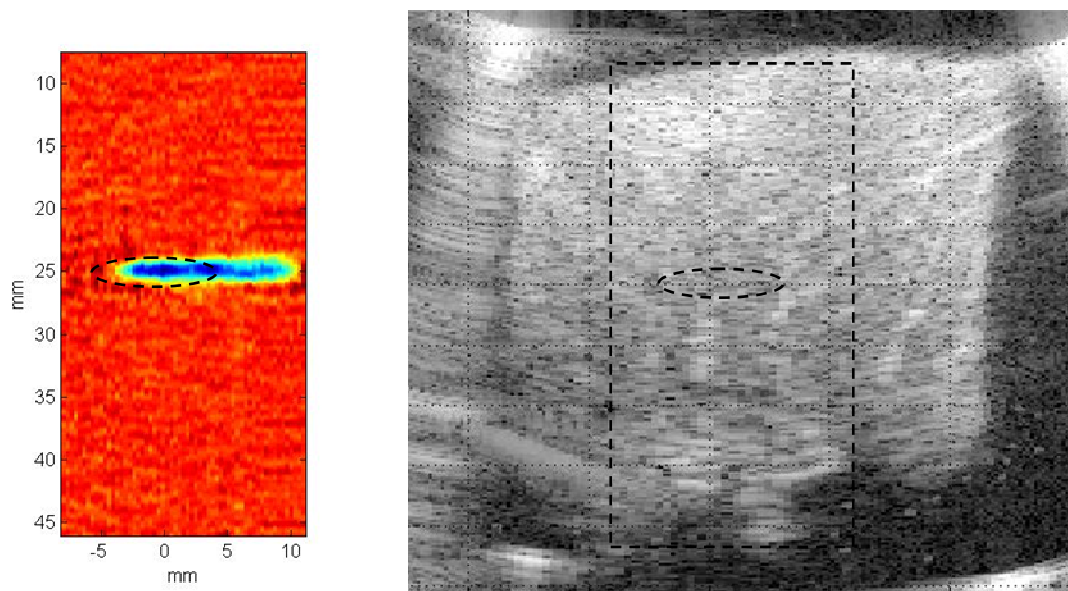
Left: AOI image of HIFU lesion in chicken breast. The HIFU focal zone is shown by the dashed oval. The tissue was scanned in increments of 1/3 mm in the horizontal dimension. Right: A standard B-mode ultrasound image of the same tissue where the dashed rectangle represents the area of the AOI image shown at left. The lesion was not visible in the B-mode image. Lesion was 4mm thick, 14mm long.
